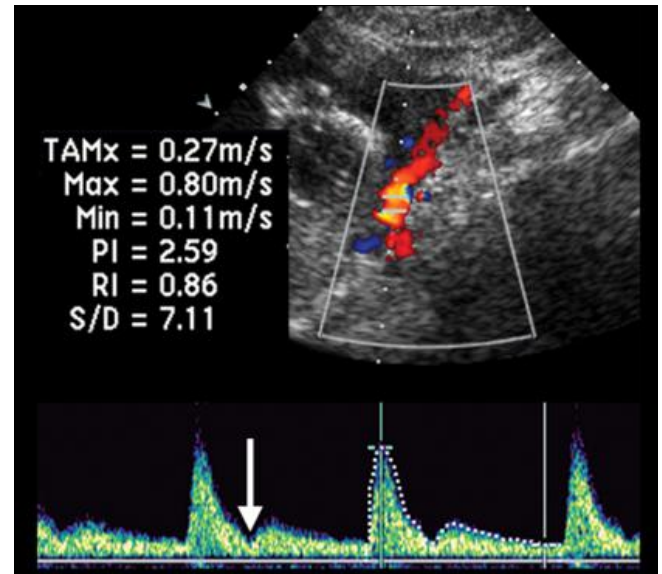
Color Doppler duplex USG image shows an abnormal waveform with presence of notch (arrow) in uterine artery diastolic wave
